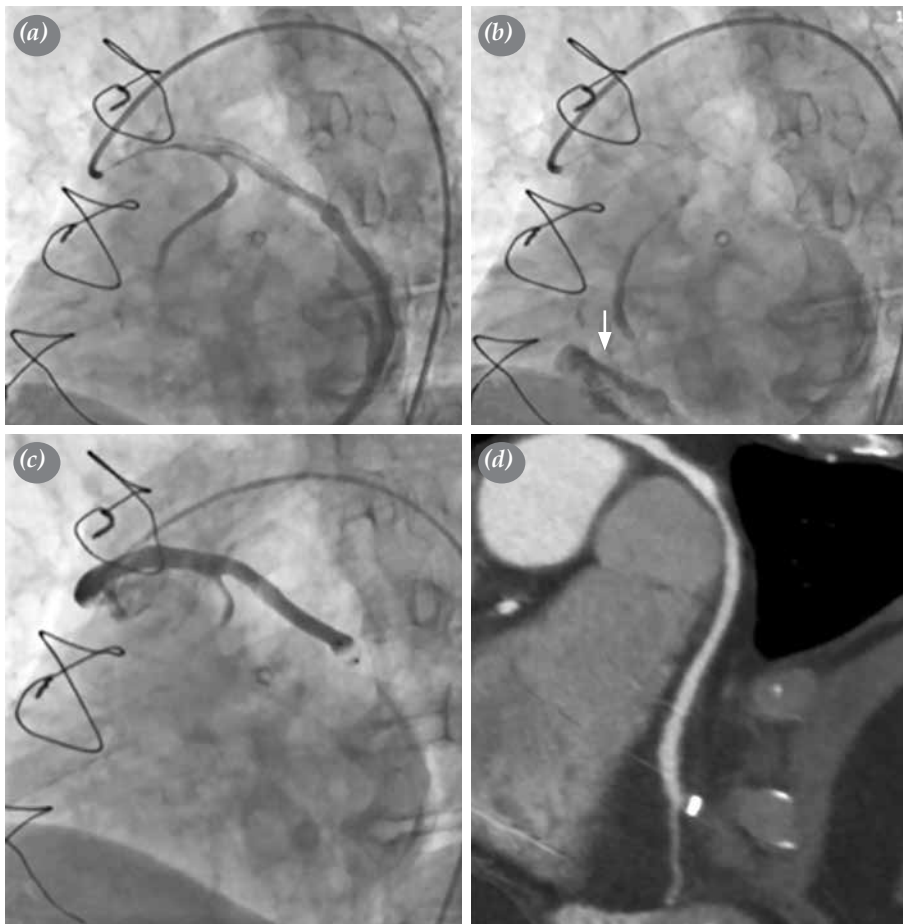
(a) Selective aorta-saphenous vein graft angiography showing an inadvertently anastomosed saphenous vein graft to great cardiac vein. Obtuse marginal graft is weak due to steal. (b) The graft consequently flowing into right atrium [white arrow]. (c) The occluder's (Amplatzer Vascular Plug II, 6-mm) placement to appropriate location and control angiography showing complete occlusion of acquired fistula. (d) Post-procedural cardiac computed tomographic angiography showing appropriate position of occluder and complete occlusion of fistula.
